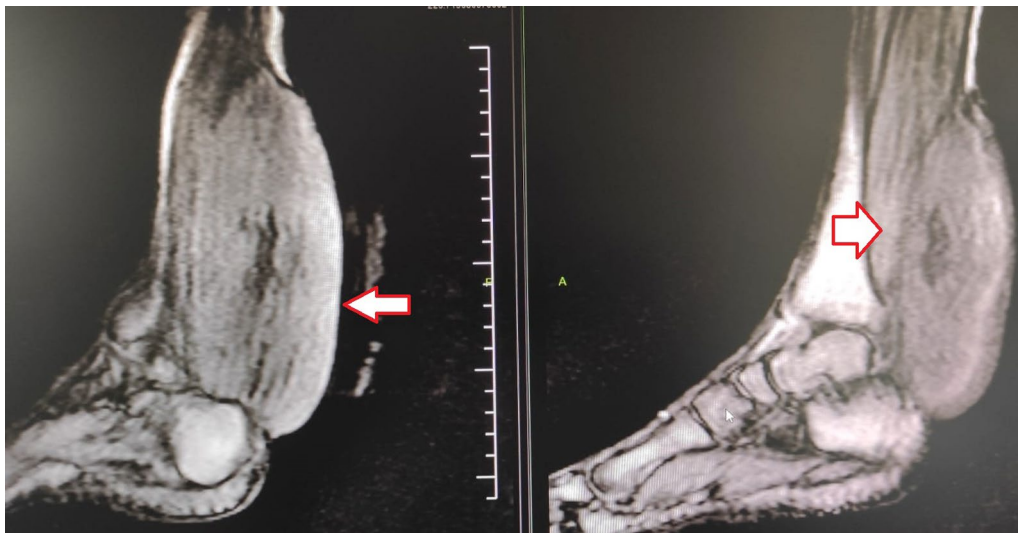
Xanthomas on MRI of the lower extremities
